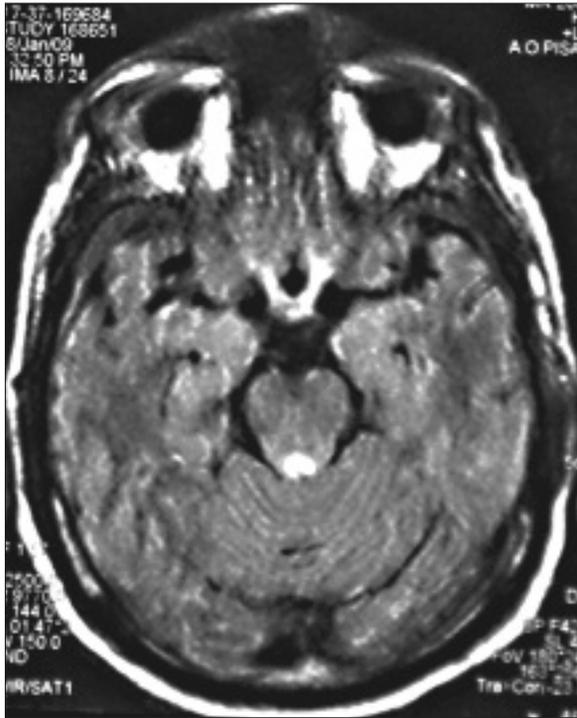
MRI of the patient's brain: T2 sequence demonstrated severe swelling of the optic nerves and chiasma.
